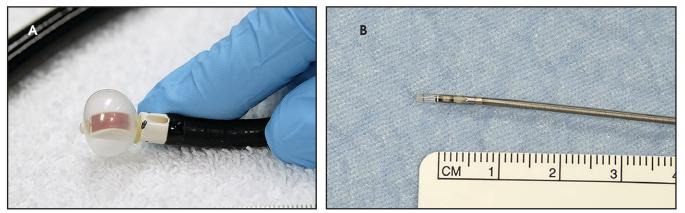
(A) Convex endobronchial ultrasound (C-EBUS), and (B) radial ultra-miniature ultrasound probe (R-EBUS).
